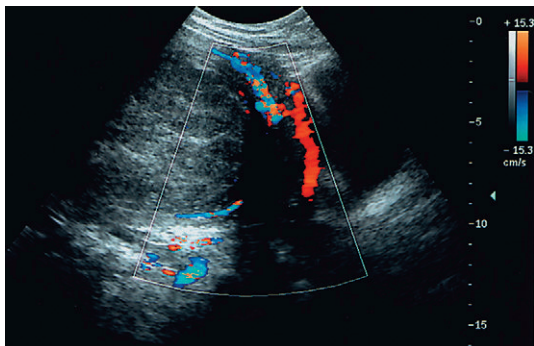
Transabdominal ultrasound demonstrates flow in normal uterine arteries (red) and a junctional vessel between the uterus and the fibroid said to be characteristic of fibroid disease.
